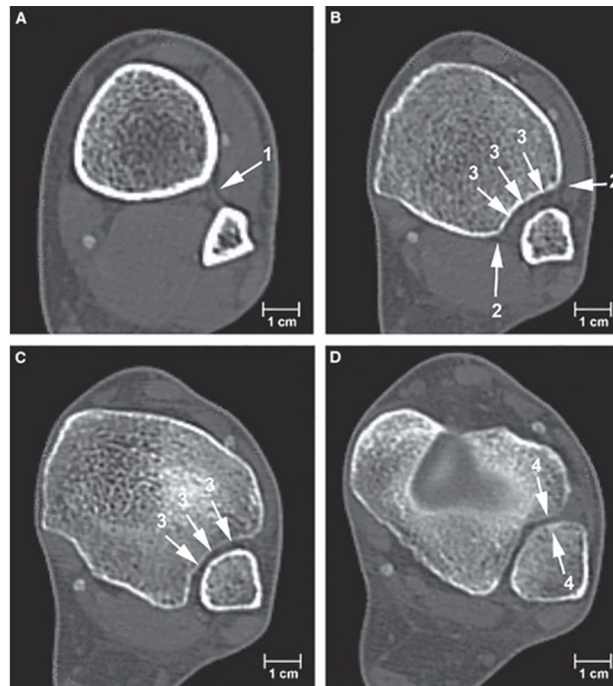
Ankle axial CT images At the level of the distal tibiofibular joint, from A (cranially) to D (caudally). 1 interosseous membrane; 2 anterior and posterior margins of the tibial incisure; 3 interosseous ligament extends to 1 cm above the tibiotalar joint. 4 flattened aspect of the incisure at the level of the ankle joint.
